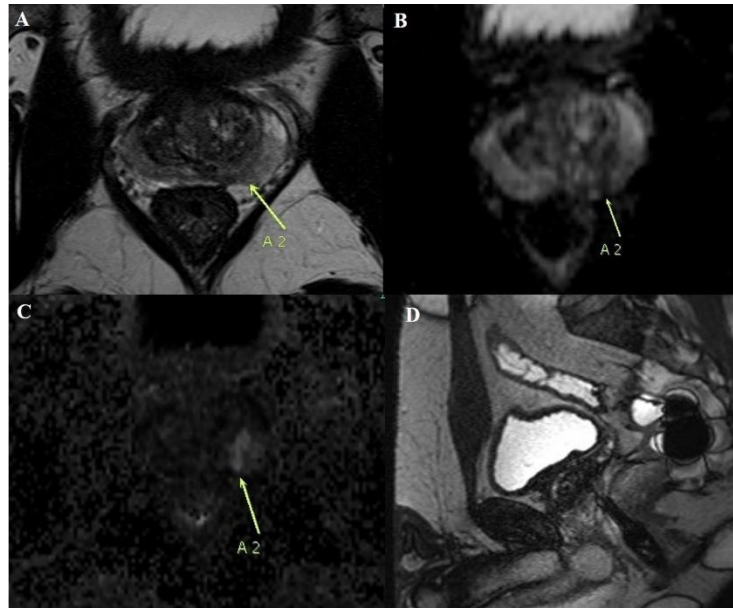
A 58-year-old man presenting with elevated PSA (5.4 ng/mL). (A) Axial T2W image shows area of hypointensity in the left peripheral zone. The mass shows low signal intensity on ADC map (B) and high signal intensity on calculated high b-value ($b=1600 \text{ s/mm}^2$) DWI (C) (arrow). The PI-RADS assessment category is 4. (D) Note the biopsy needle directed to the target area. Target biopsy revealed prostatic adenocarcinoma, Gleason score 8(4+4) involving 48% of 5 cores.
